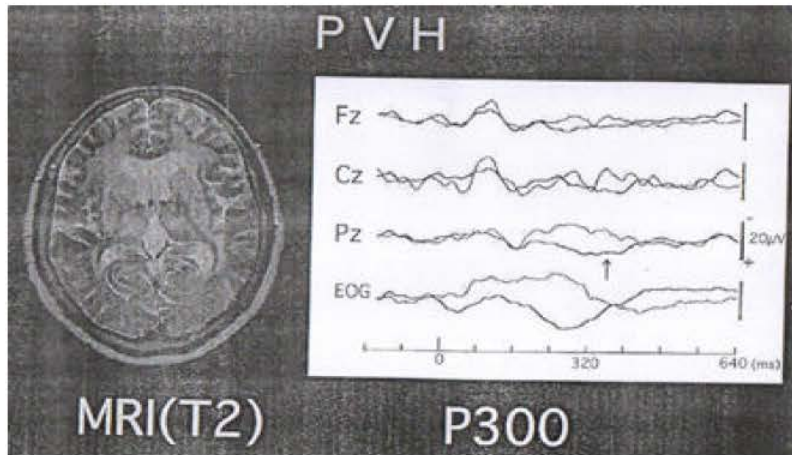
The MRI of leuko-araiosis or periventricular high intensity without asymptomatic lacunar infarction in T2-weight image with prolonged P300 average waveforms of ERPs obtained from Fz, Cz, Pz and EOG in responses using a standard auditory oddball stimulus paradigm
